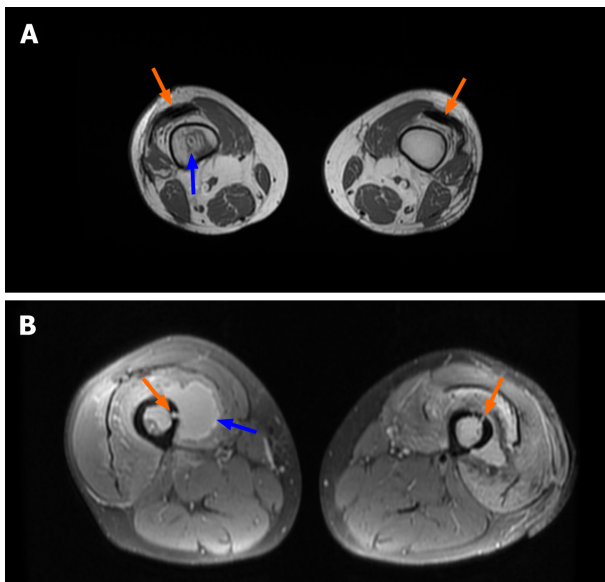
MRI scan of both thighs, axial section. A: Orange arrows indicate air inserts in interfascial spaces. Blue arrow indicates an abscess in the intramedullary space in the right femur. B: Fistulas are marked with orange arrows merging with the intramedullary space, present bone destruction. The blue arrow indicates a clearly visible abscess around the femur.
